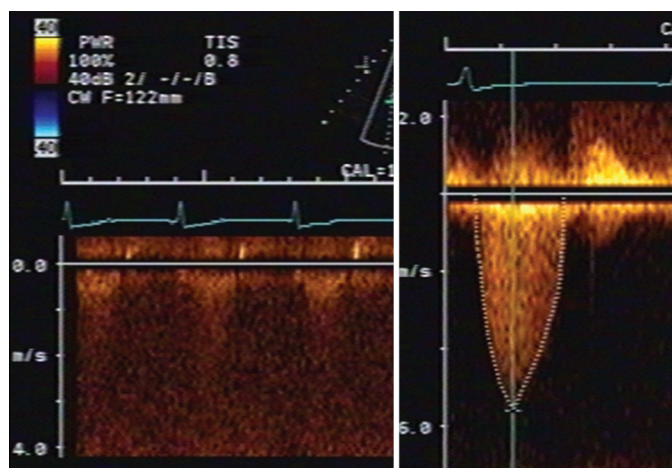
Baseline unenhanced Doppler spectra (left panel) in this patient with valvular aortic stenosis are indistinct. Following administration of contrast material (right panel), the CW spectra are clearly defined.
